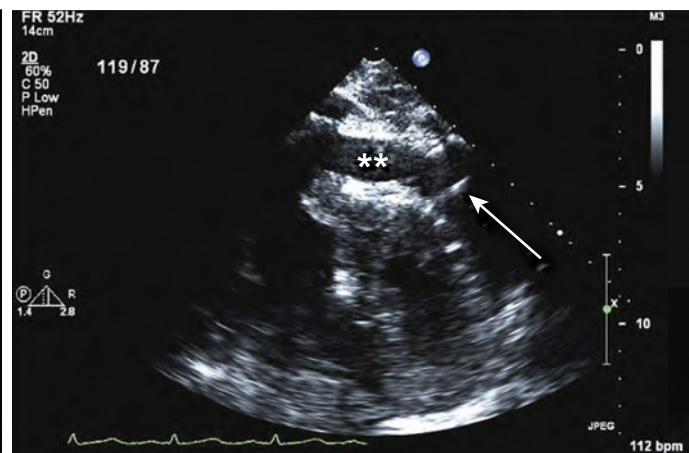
Two transthoracic echocardiographic short-axis views of the heart show a needle (arrow) advanced into the pericardial space (double asterisks) under echocardiographic guidance.
